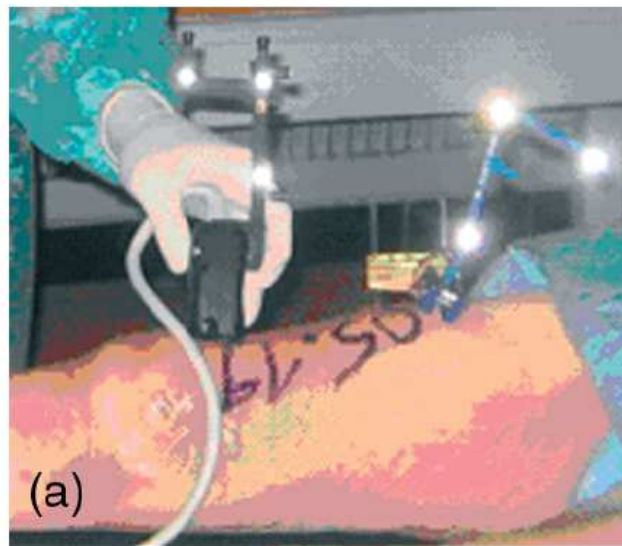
Snapshot for the scanning of the cadaveric knee using the tracked ultrasound probe by Kilian et. al. [15]
